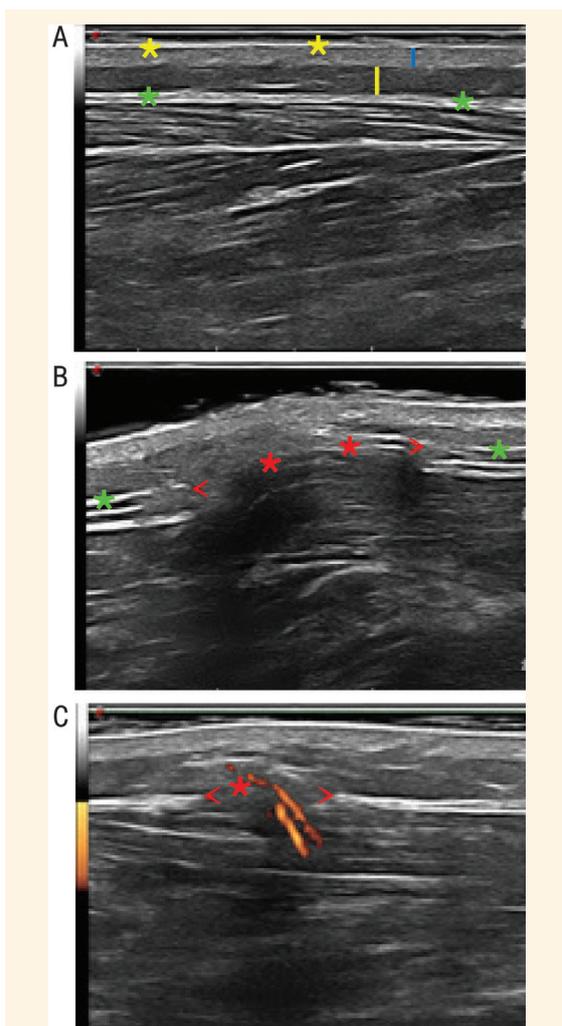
A: Ultrasound image of the lateral side of the left leg of a 28-year-old male patient in a sitting position with no pathological findings showing the epidermis (yellow asterisks), dermis (blue line), subcutaneous tissue (yellow line) and muscle fascia (green asterisks). B: Ultrasound image of the same patient in a standing position showing a disruption in the integrity of the fascia (red arrows), resulting in a muscular herniation through the fascial plane (red asterisks). The normal muscle fascia can be seen beyond the hernia (green asterisks). C: Doppler mode ultrasound image of the same patient in a standing position showing blood vessels (red asterisk) going through the fascial plane at the sites of muscular herniation. Red arrows indicate the margins of the hernia.
